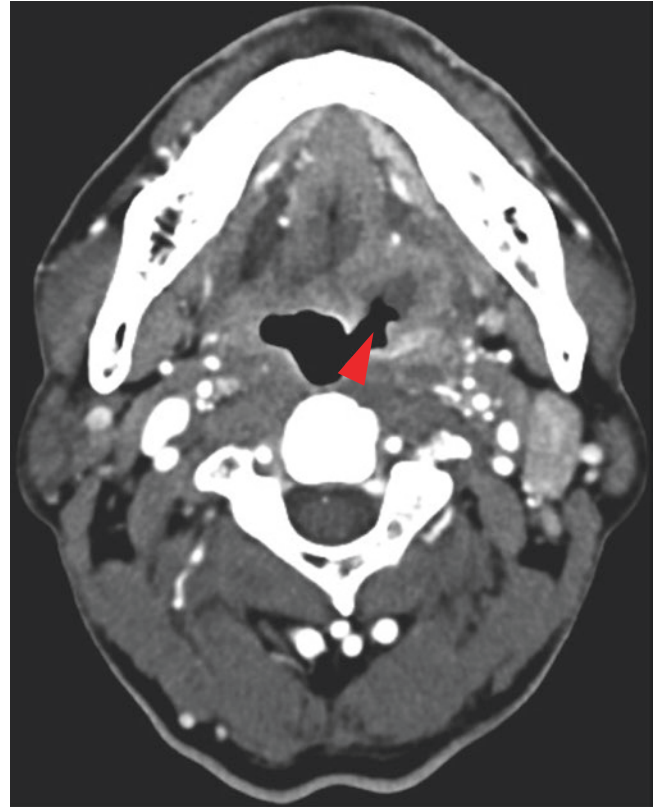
Non-HPV-associated oropharyngeal SCCa of the left base of the tongue. Contrast-enhanced CT image shows an ill-defined mass with ulceration (arrowhead) at the left anterior wall of the oropharynx
